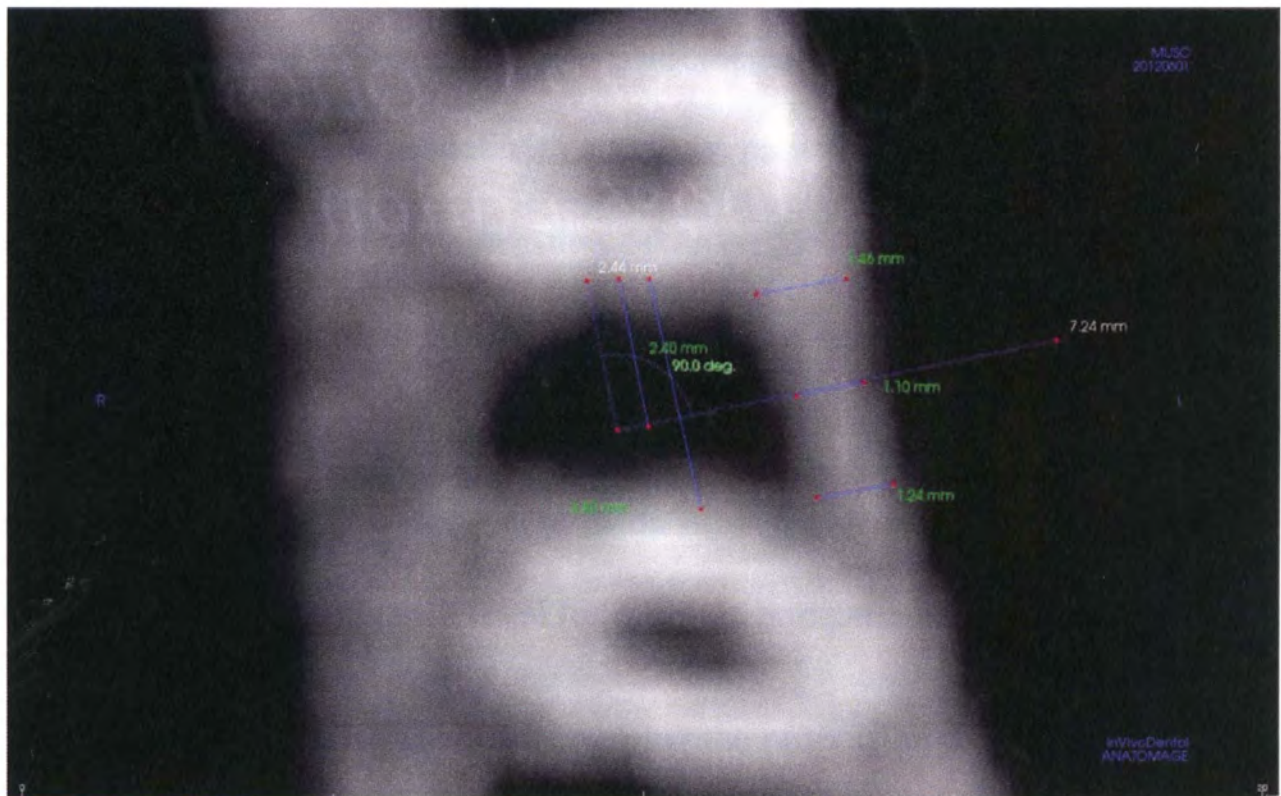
CBCT cortical bone thickness measurements. This is the view utilized in steps 5-7 of the orientation process for each CBCT evaluated showing all of the measurements made at each location.
